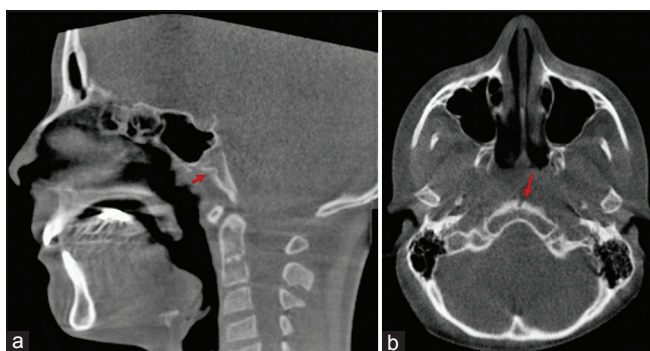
The appearance of fossa navicularis magna on the cone-beam computed tomography sagittal section (a) and axial section (b)
